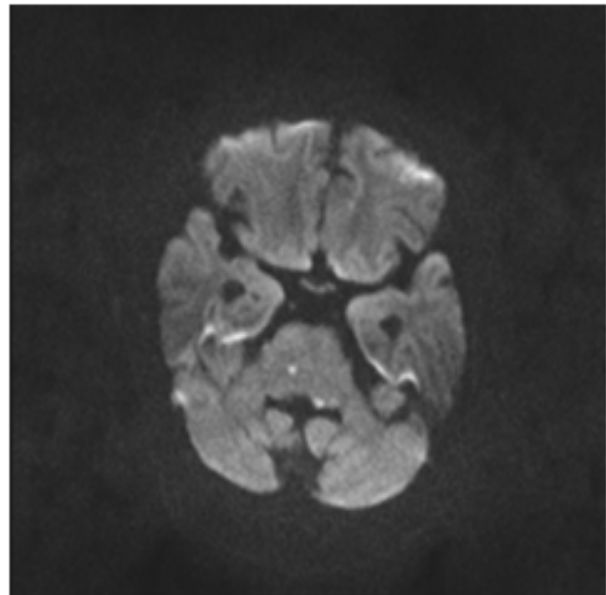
MRI brain indicating acute infarction in pons.
